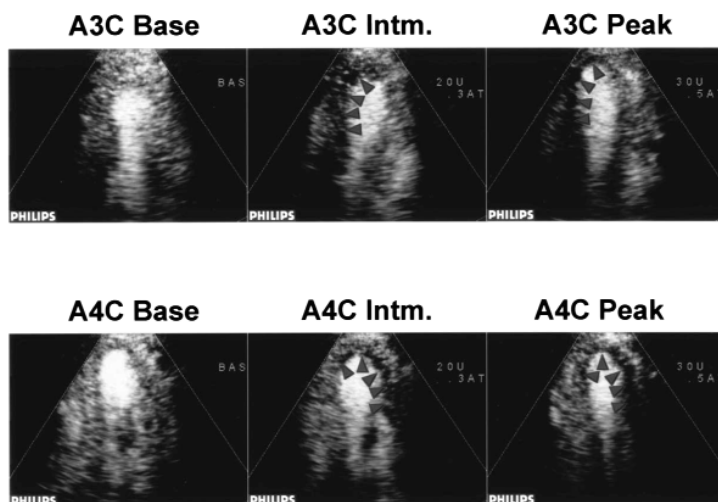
Echocardiographic images from the apical four-chamber and three-chamber views, at rest, intermediate stage (Intm), and peak stage of dobutamine stress in a patient with left anterior descending (LAD) and left circumflex (LCx) coronary artery disease (CAD). Perfusion abnormalities were evident in the lateral, posterior, and apical segments at intermediate phase with extension of these abnormalities at peak stress (arrows). The patient had inducible wall motion abnormalities confined to the apex at peak stress.
